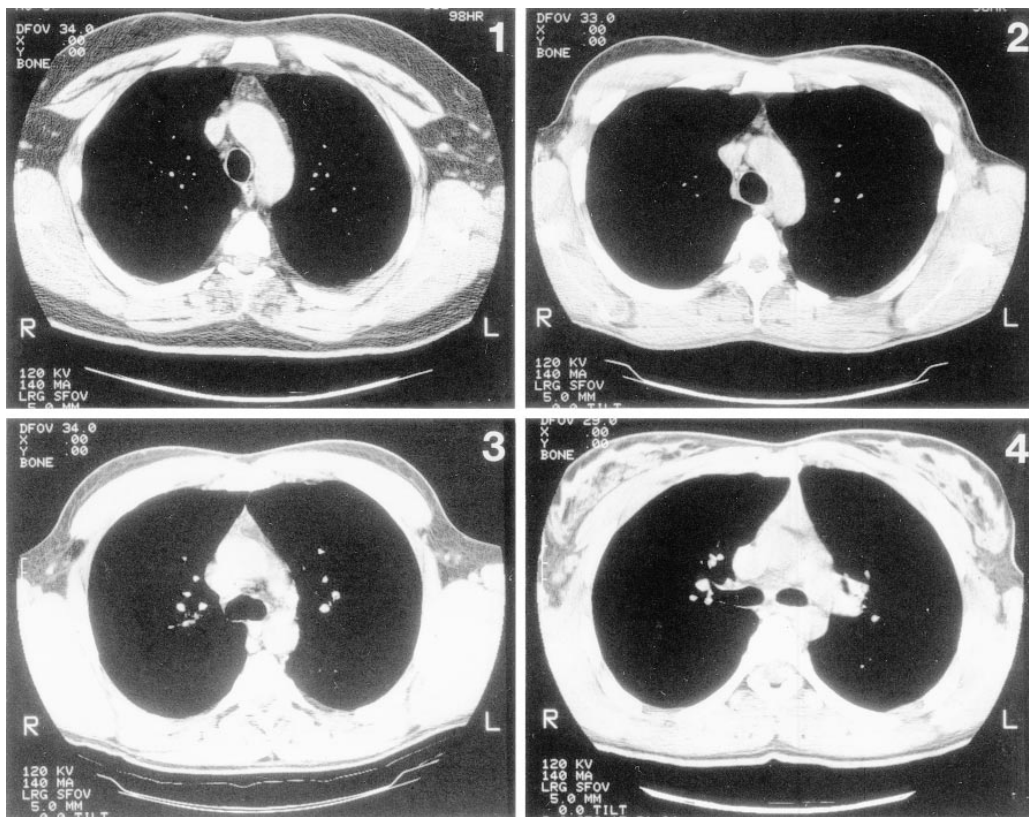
Visualization of the thymus in HIV-1-seropositive adults by computed tomography. Representative CT scans are shown corresponding to thymic index scores of 1, 2, 3, or 4. The thymus is the triangular-shaped mass at the top center of each frame, most obvious in frames 3 and 4.
